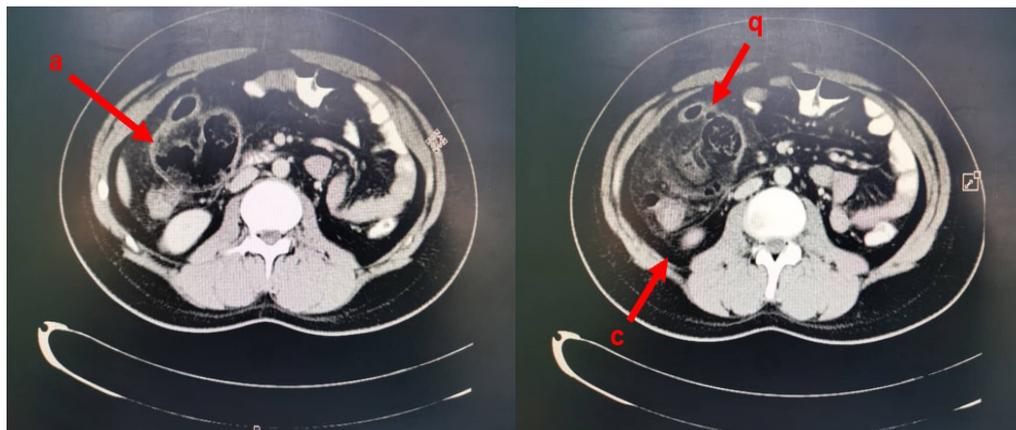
CT abdomen showed dilated loop of terminal ileum at right iliac fossa with fecal intraluminal appearance suggestive of sub-acute bowel obstruction (a) with free air at superior aspect of this loop (b) as well with free fluid seen in right paracolic gutter (c).
